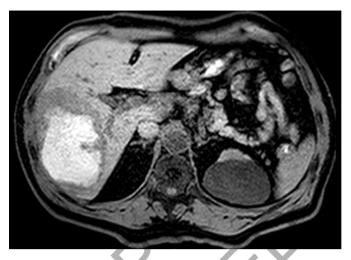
MRI scan of the liver metastasis.
